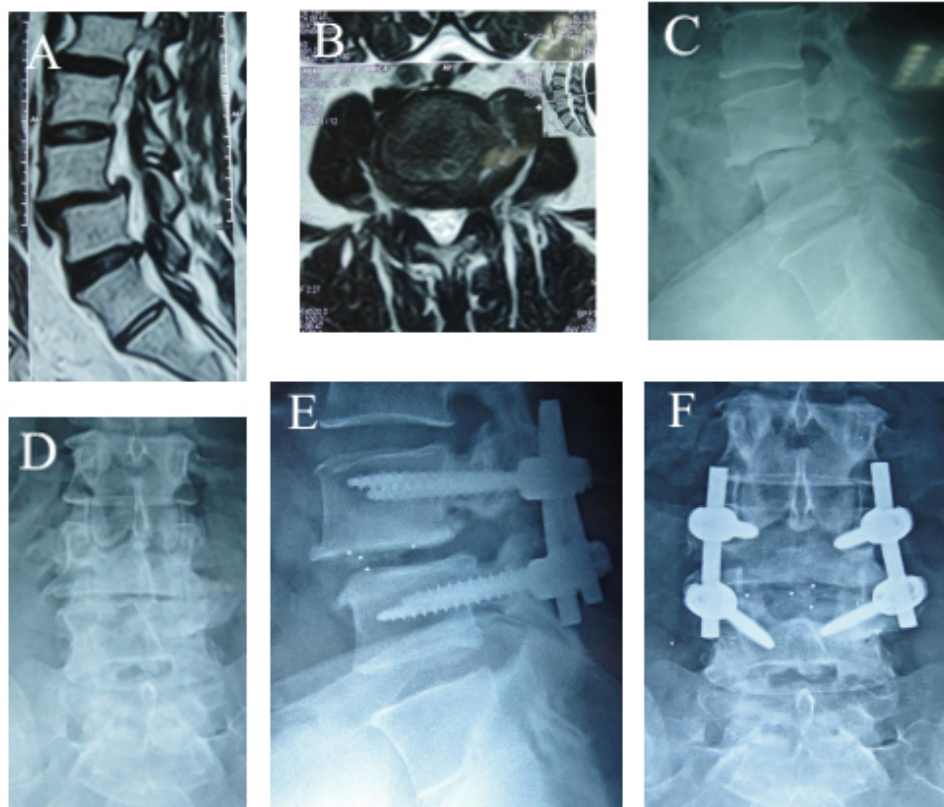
(A- F) A. T2 sagittal MRI lumbosacral spine showing L3-4 spondylolisthesis. B. Axial view L3-4 disc. C- D. plain x-ray lateral and A-P view showing spondylolisthesis with fracture pars. E.-F. Postoperative plain x-ray L3-4 transpedicular screw fixation with transforaminal interbody fusion with reduction of the step.
